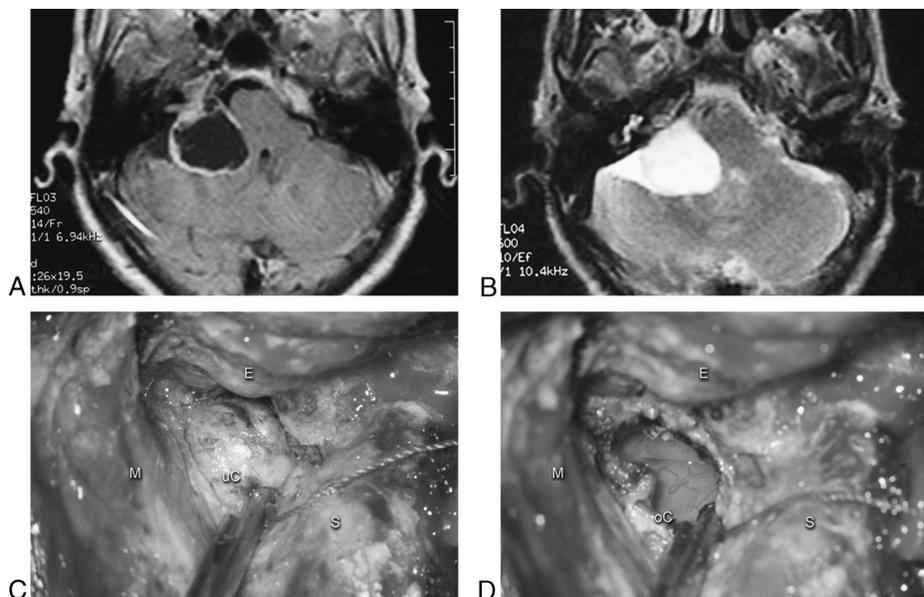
Right Type B4 CVS that was recently operated at our institution through a translabyrinthine approach. *A*, Preoperative axial T1-weighted image with contrast showing a right CVS. *B*, Preoperative axial T2-weighted image of the same lesion. *C*, Intraoperative photograph showing the unopened CVS (*uC*) through a translabyrinthine approach. *D*, Intraoperative photograph showing the opened CVS (*oC*). The vessels lying between the thin cyst wall and the brainstem were visible (*D*). Middle fossa dura (*M*), bony external auditory canal (*E*), and sigmoid sinus (*S*).
